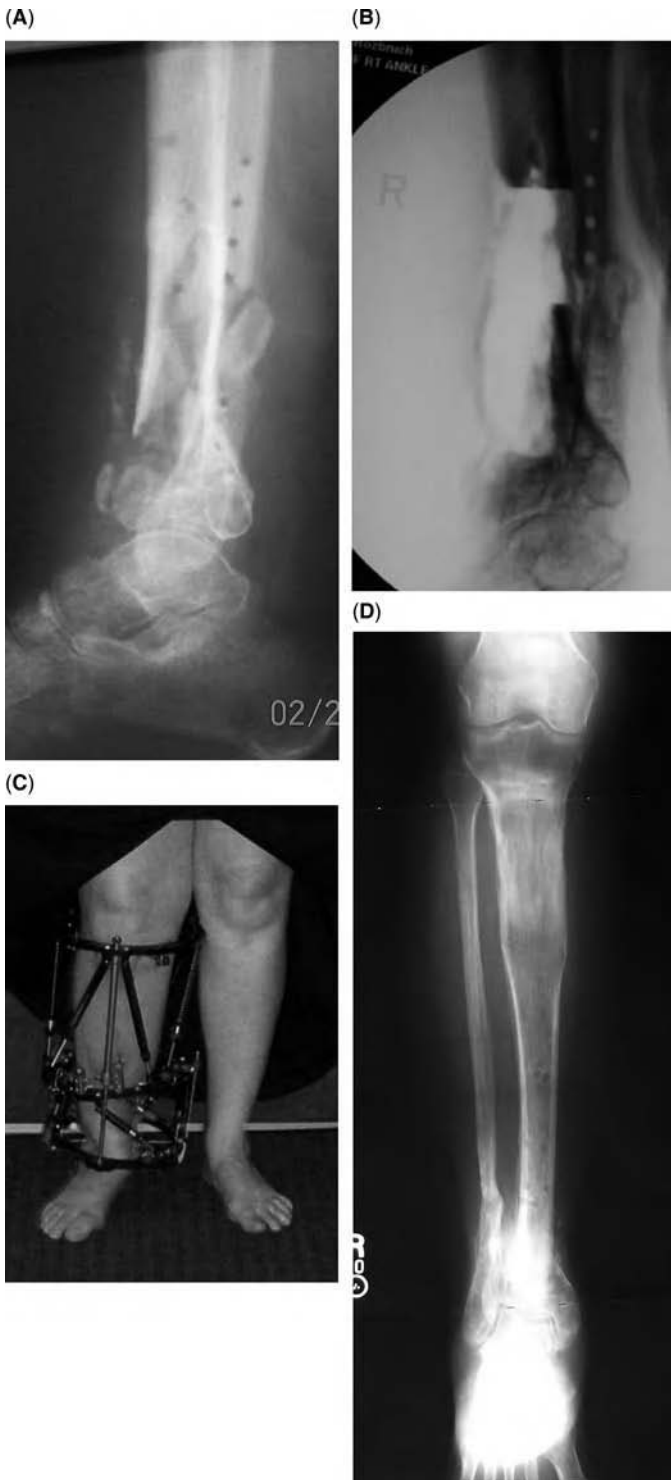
(A) Lateral X-ray showing an infected nonunion of the distal tibia. (B) Intraoperative X-ray after resection of dead infected bone. Note the 8 cm defect. (C) Standing front view showing a bone transport Ilizarov/Taylor spatial frame. (D) Anteroposterior radiograph three months after frame removal showing a successful bone transport with 8 cm proximal tibia lengthening and healed docking site at the distal tibia.
